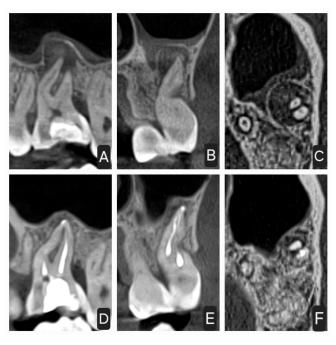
CBCT images of tooth 2.7. Coronal, sagittal, and axial CBCT images before (A–C) and after treatment (D–F). The three-dimensional CBCT study reveals an osteolytic lesion measuring $9 \times 9 \times 6$ mm at the apical level, affecting the mesiobuccal and distobuccal roots. Comparing images C and F, it can be observed that, after 1 year of laser therapy, the lesion had satisfactorily resolved.
